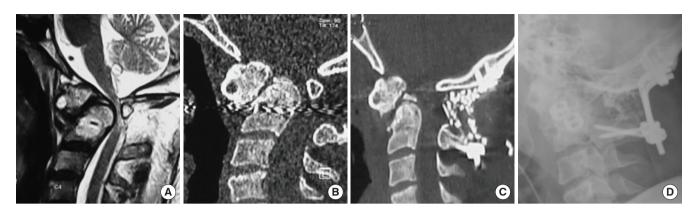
A 34-year-old male had a fall from a tree 4 months ago (case 6, Table 1), following which he developed complete quadriplegia. He was provided treatment at a local hospital with traction and other medical treatment (possibly also methylprednisolone, but details were not available). He improved over the next month but was severely hindered (Nurick score was 4) and severely restricted neck movements. On referral to us, magnetic resonance imaging (A) showed a type II dens fracture with a large ventrally displaced fragment wedged between the C1 arch and the C2 body (computed tomography scan; B) with evidence of severe cord compression. (C, D) Following a modified distraction, compression extension, and reduction as described in the text, there was a satisfactory fracture reduction. The effective canal diameter improved b 83% and the actual canal diameter by 63% (see Table 1).
